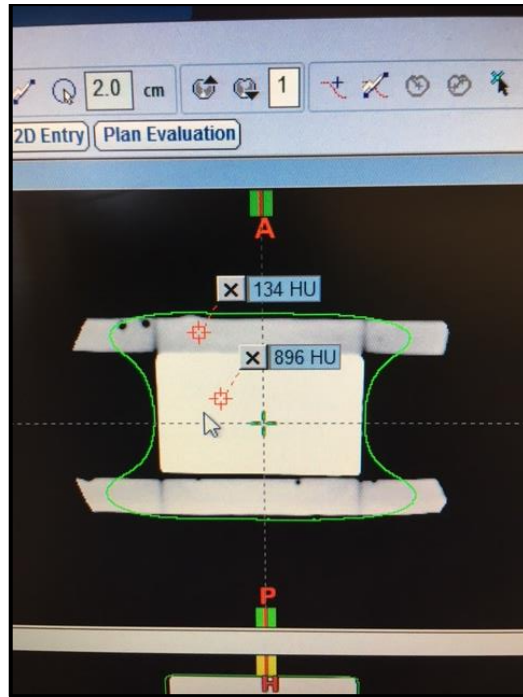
CT scan of Encapso K to verify density
